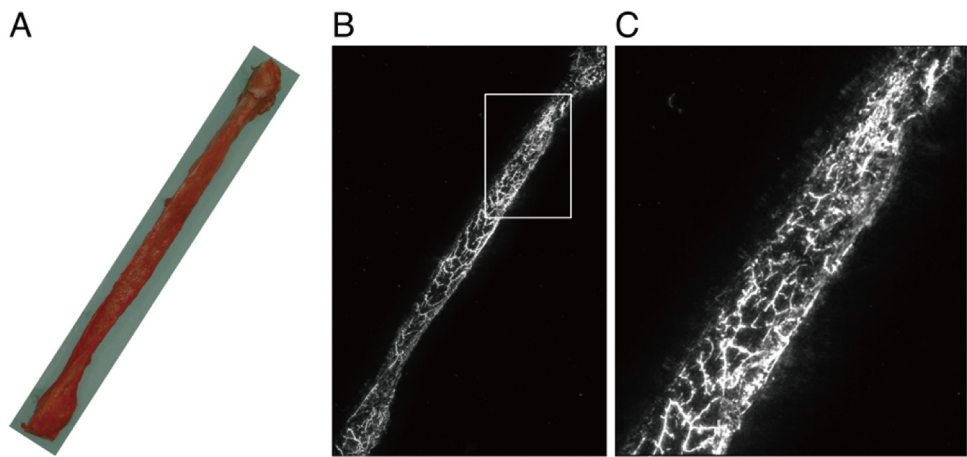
Identification of an non-penetrating periosteal vessels (NPPVs) by photoacoustic imaging. A) Gross findings of the dissected fibula. B) Photoacoustic image of the periosteal nutrient vessels (low magnification). C) Partially magnified image. The photoacoustic imaging system provides NPPV imaging quality similar to that with X-ray angiography.
